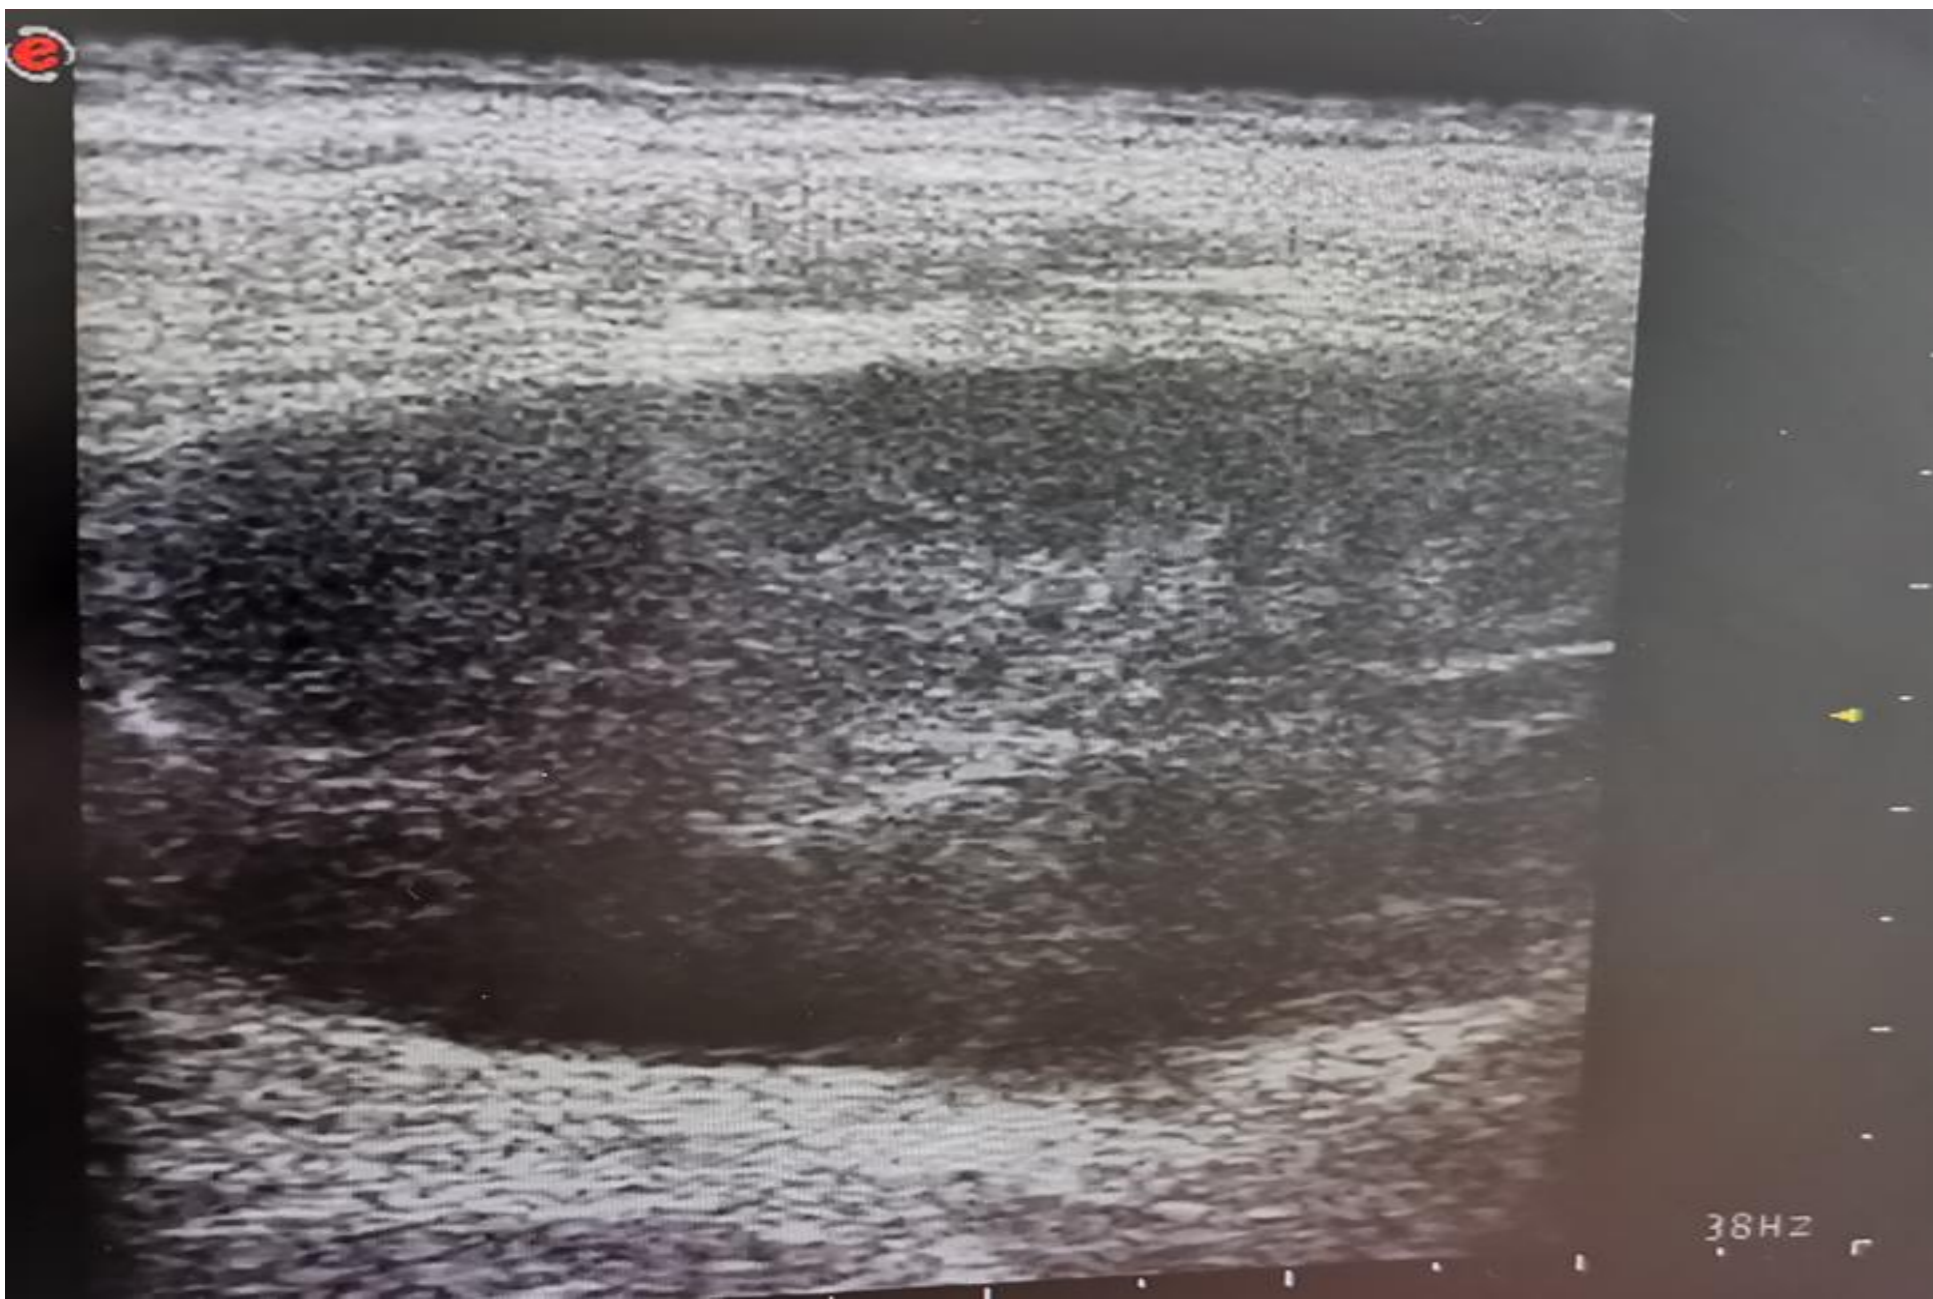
Ultrasonography upper limb, tumoral formation
